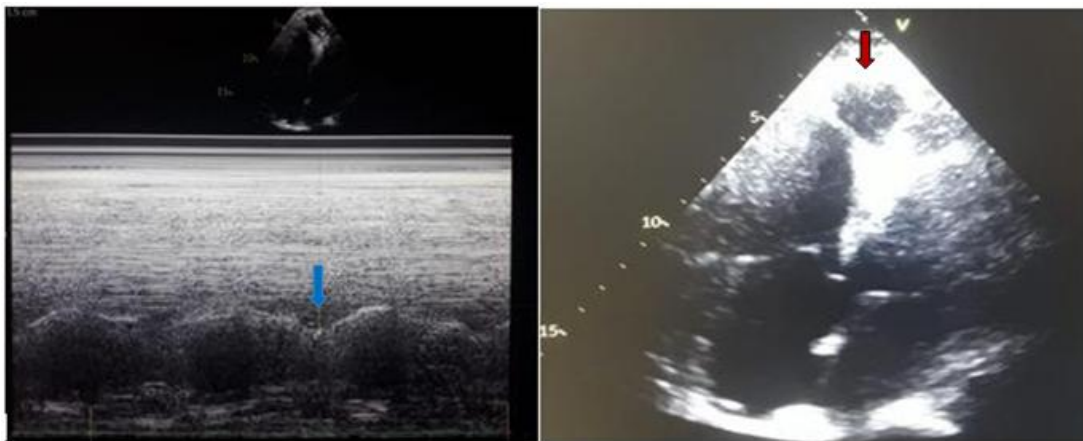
TTE- Apical four chamber window. Anevrism of the apex (red arrow); Right ventricular impaired systolic function: Tricuspid annular plane systolic excursion (TAPSE) =15 mm (blue arrow)
